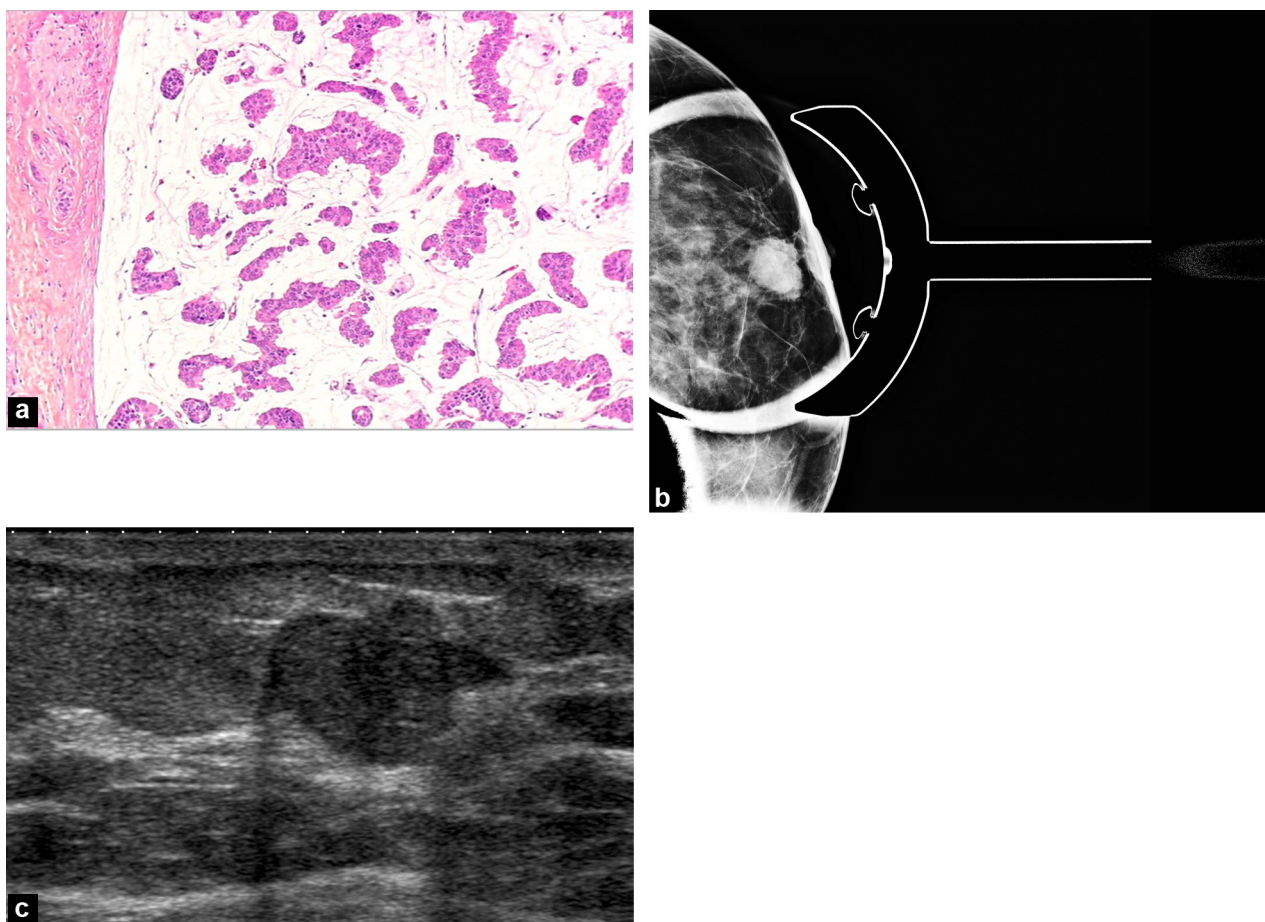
Mucinous cancer. a: HES $\times 25$. Cluster of tumoral cells floating in pools of mucus; b: mammogram, spot compression: oval mass with a slightly microlobulated edge; c: sonogram: mass parallel with microlobulated edge, isoechogenic with posterior enhancement.
